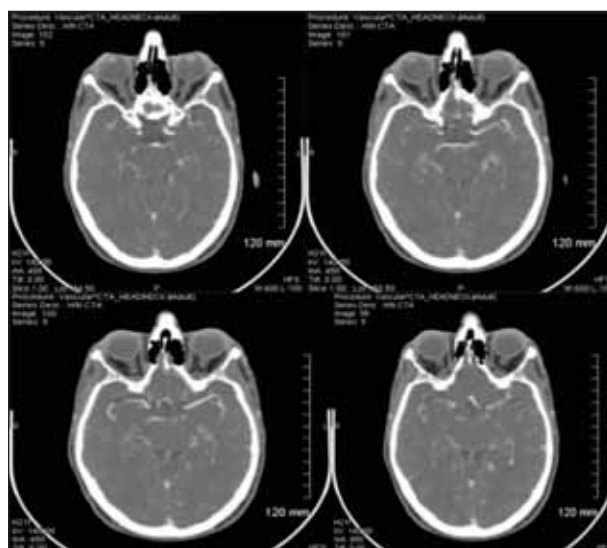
Consecutive CT angiograms showing poor opacification of the right MCA branches consistent with an embolic/thrombotic event.
